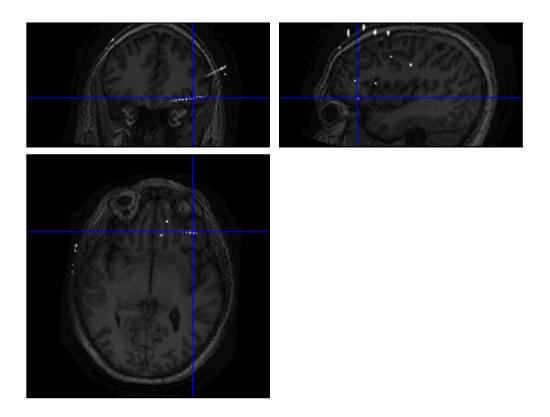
Coronal (top, left), sagittal (top, right) and axial (bottom) sections of the computed fusion of the pre-MRI with the post-CT of a representative patient in SPM8. Crosshairs indicate a contact of a depth electrode implanted in the OFC.
